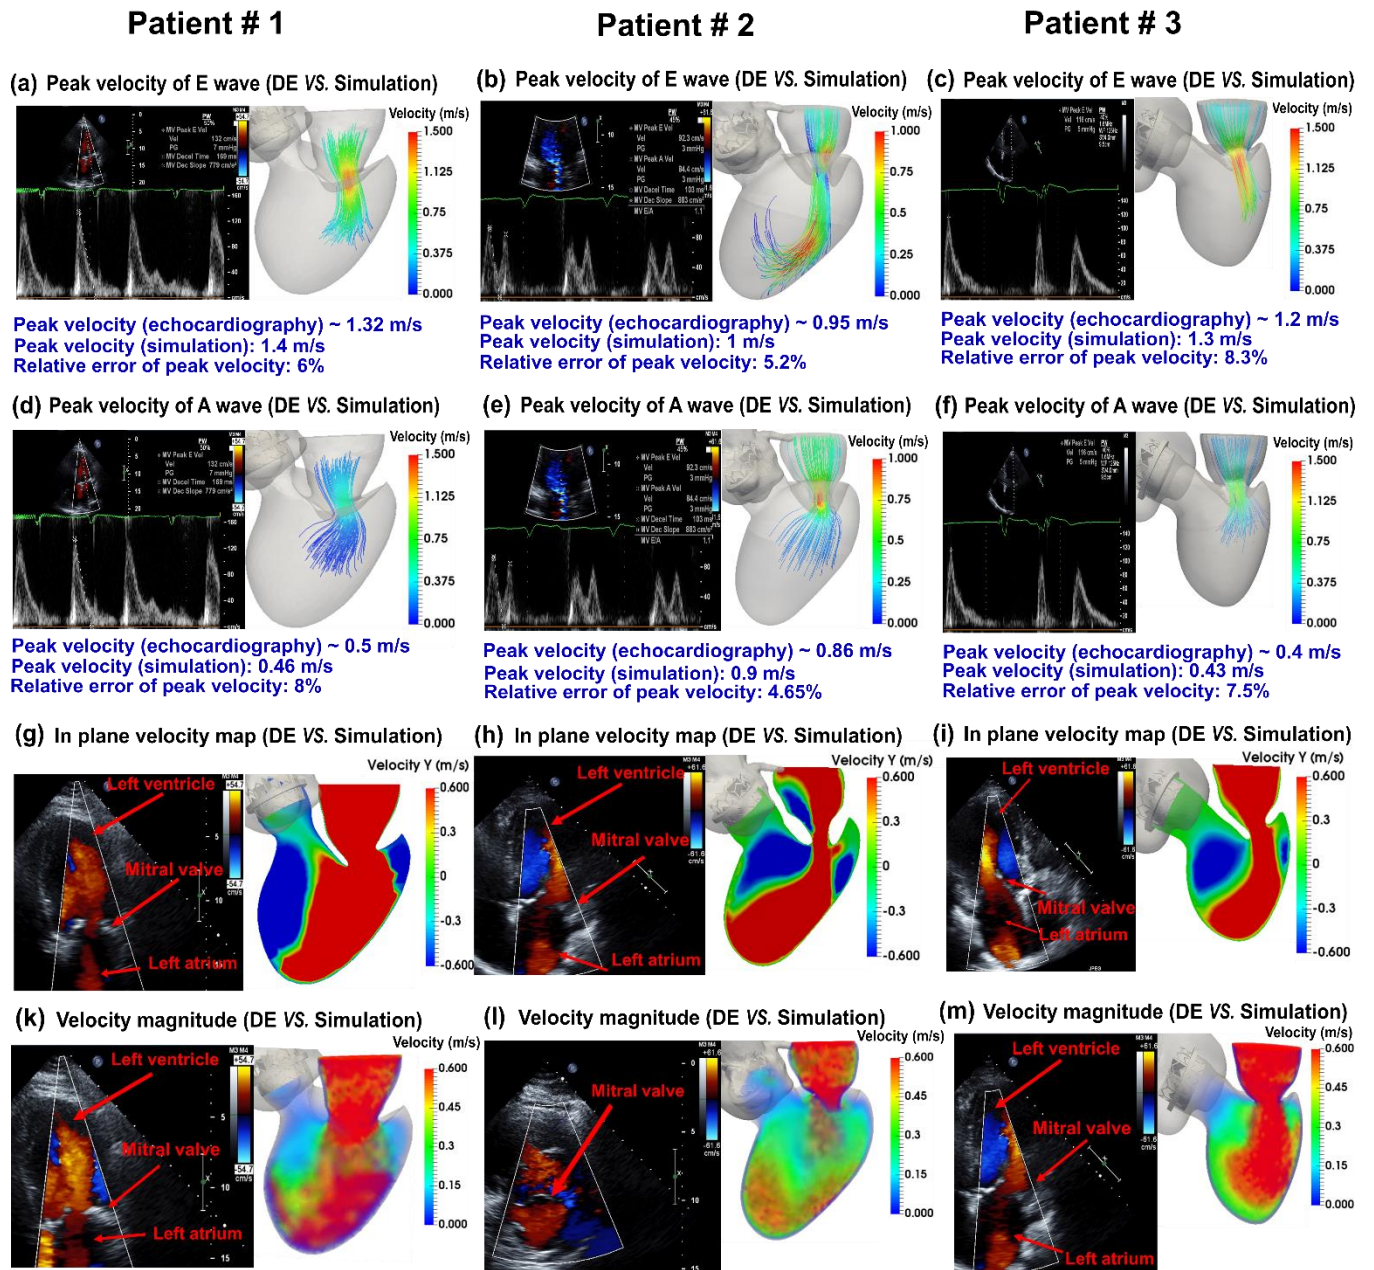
Validation: Doppler-based LPM and FSI framework vs. Clinical Doppler echocardiography data in post-TAVR condition. (a) to (f) Trans-mitral velocity during diastole in patients #1 to #3; (g) to (i) Left ventricle flow (apical view) during diastole in patients #1 to #3; (j) & (l) Trans-mitral and left ventricle flow (apical view) during diastole in patients #1 and #3; (k) Mitral valve flow (parasternal short axis view) in patient #2.
